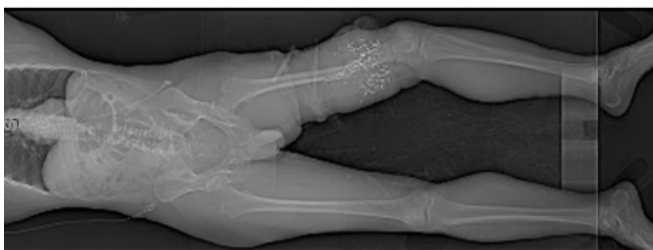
Computed tomography scout film, showing absence of pelvic pellet
